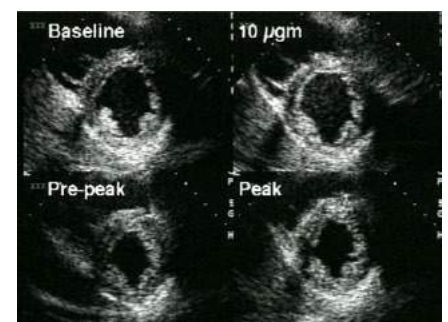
Dobutamine Stress Echocardiography, showing the parasternal short axis images in quad view for direct comparison at rest, low-dose, mid-dose and peak dose dobutamine. There is thickening of the myocardium with a smaller LV cavity with increasing dobutamine dose, which is the normal response to stress.
